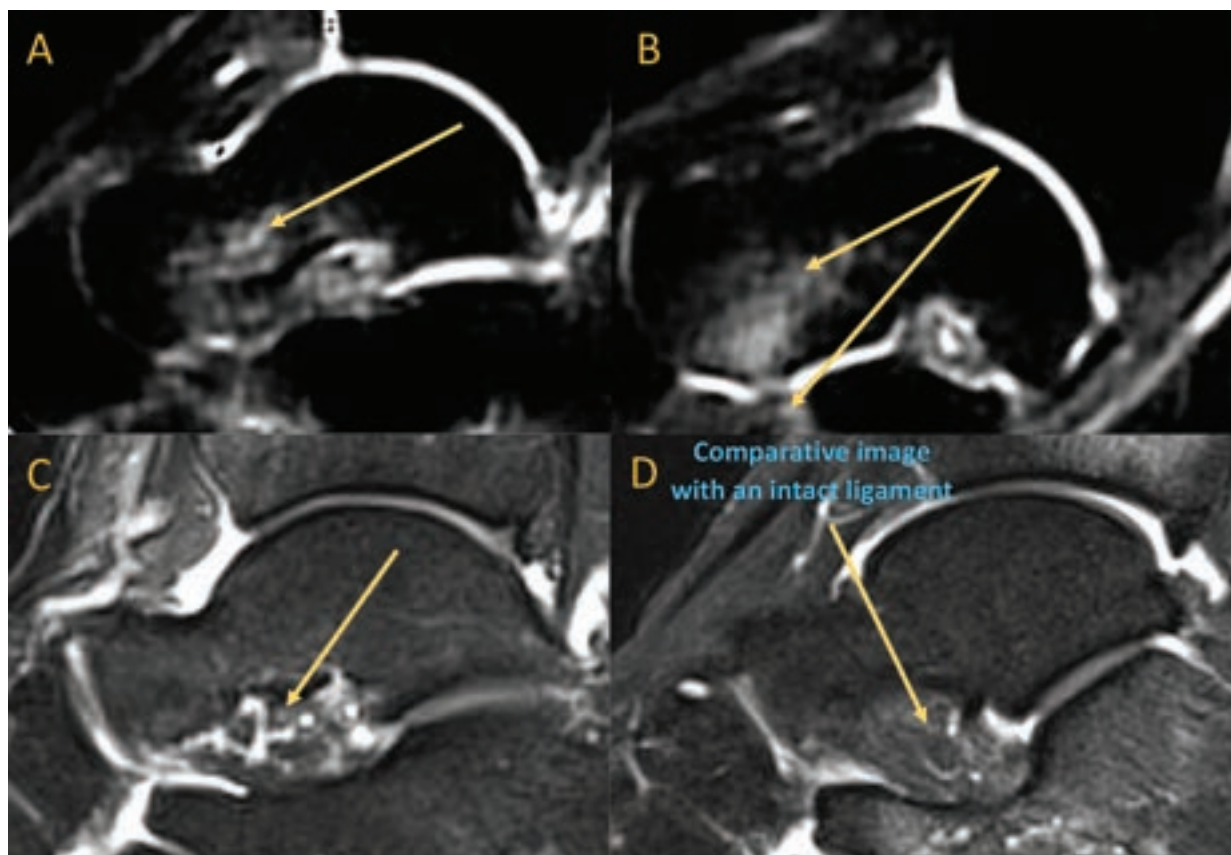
to 1D. (1A and 1B) Injury MRI images: Bone bruises at the cervical ligament footprint at the talus and calcaneus. (7 weeks after injury) (arrows) (1C) Pre-operative MRI: resolution of bone edema with interrupted cervical ligament fibers (8 months after injury). (arrow). (1D) Sagittal MRI of another patient to show intact cervical ligament (arrow).
